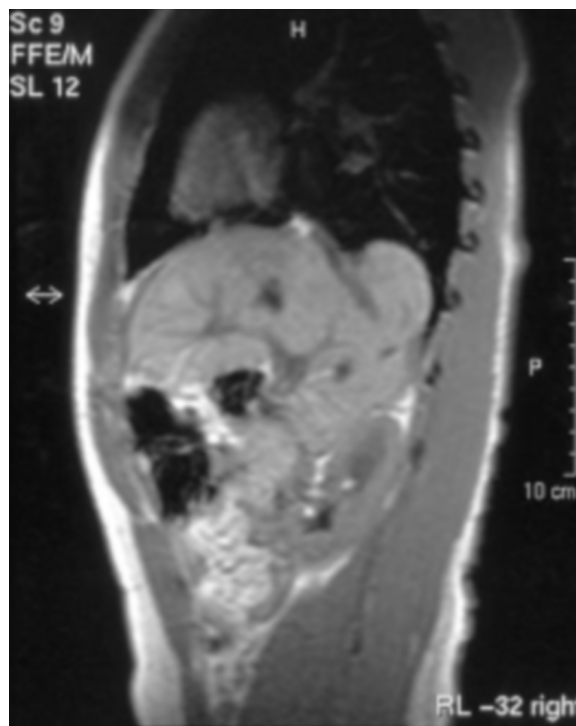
Sagittal T1-weighted MRI shows the herniated portion of liver.
